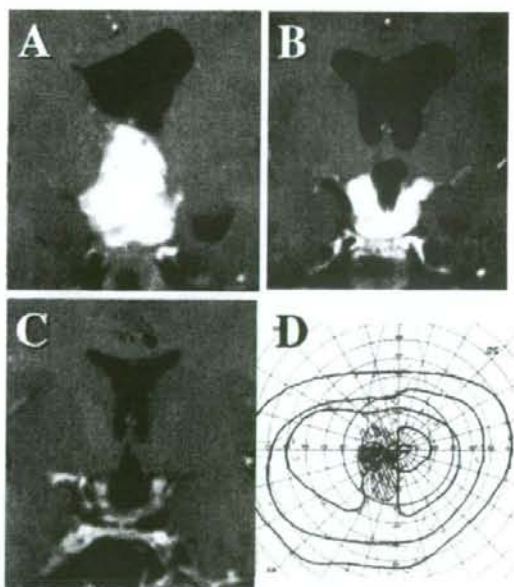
A relapsing tumor (A) in a 7-year-old boy, who had received chemotherapy for 7 years following a partial resection. MR image shows a homogeneous tumor, but the tumor infiltrating the chiasm and the hypothalamus was relatively firm, and only the soft mass filling in the third ventricle was selectively resected (B). Five years later, when the patient was 13 years old, the residual tumor had spontaneously shrunk, and visual function was preserved (C and D).
